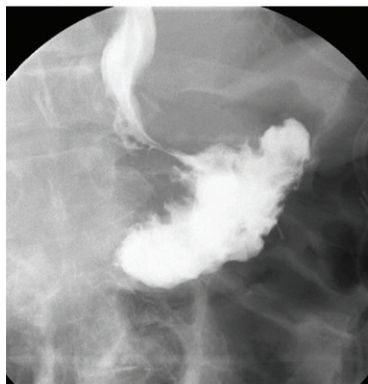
(18) Dehiscence of an anastomosis with a skin fistula after transhiatal esophagectomy. (a) Axial precontrast CT esophagram shows an anterolateral soft-tissue defect and disrupted suture material (arrow). (b) Axial CT esophagram obtained after oral contrast material administration confirms dehiscence of the proximal anastomosis (red arrow) and a fistula to the skin (white arrow). The contrast material leak and fistula were not evident at fluoroscopic esophagography that was performed on the same day (not shown). (19) Esophageal leak. (a) Fluoroscopic CT esophagram obtained after Heller myotomy was negative for leak. After diet advancement, the patient became progressively hypoxic, and a chest radiograph (not shown) revealed large right pleural effusion. (b, c) CT esophagrams obtained without intravenous contrast material help confirm an esophageal leak above the level of the gastroesophageal junction, with a gas-fluid collection in the right pleural space (arrow). (20) Long-segment esophageal stricture in a patient with a history of esophageal rings requiring dilation who presented with food impaction and concern for esophageal rupture. (a) Fluoroscopic esophagram suggests a stricture (arrow). However, the patient was unable to swallow additional contrast agent while standing. CT esophagography was recommended to help evaluate for leak. (b) Sagittal maximum intensity projection (MIP) reformation from CT esophagography demonstrates a long-segment esophageal stricture (bracket). No leak was evident. (c) Sagittal reconstruction from CT esophagography also shows the long-segment esophageal stricture (bracket).
